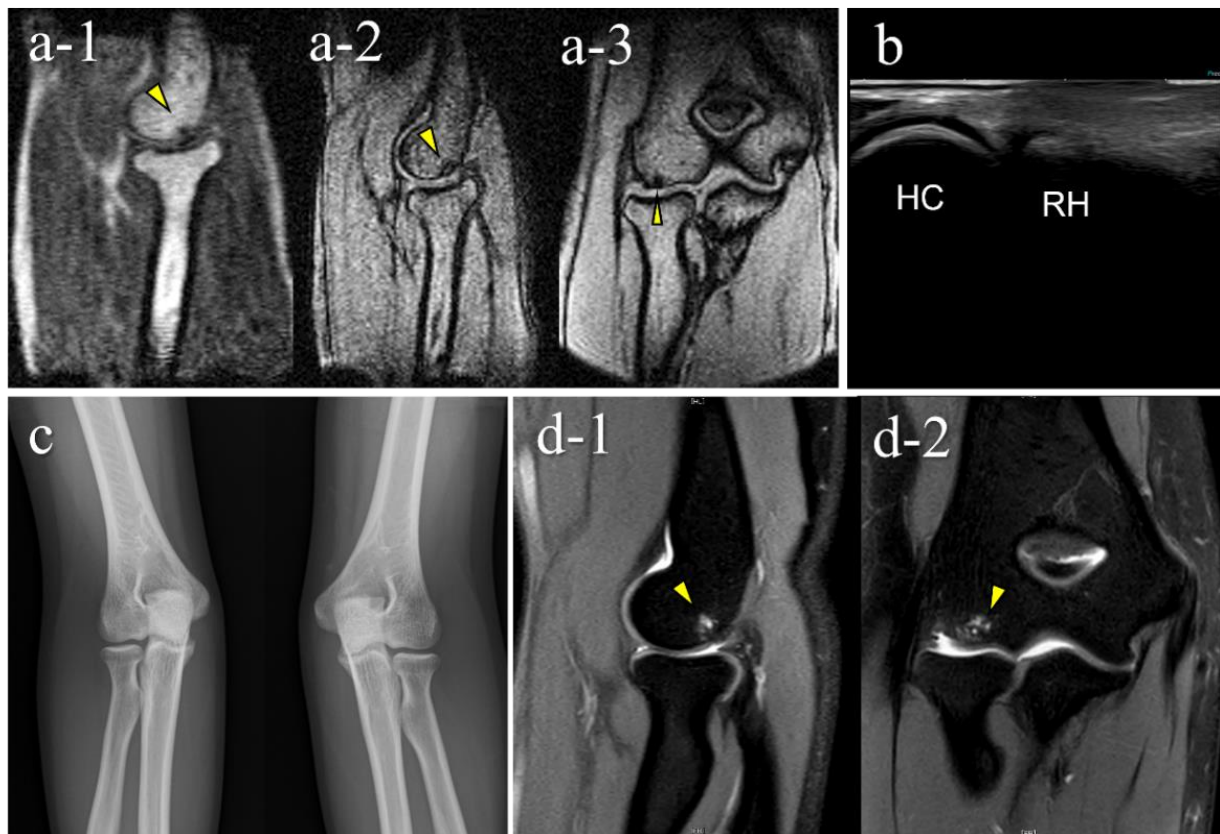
A false-positive case with mobile MRI (Case 6): Mobile MRI (+), US (-). (a) Mobile MR images: a-1, sagittal T1WI image; a-2, sagittal T2*WI image; a-3, coronal T2*WI image: mobile MR images showing a small subchondral bone-lesion in the posterior capitellum; (b) US images of the posterior longitudinal view: US did not reveal any remarkable findings; (c) X-p AP view with elbow 45° flexed: X-p 45° showed no significant findings; (d) 3T MR images: d-1, PDWI-FS sagittal image; d-2, PDWI-FS coronal image: 3-T MR image showing that the lesion was located in the posterior-central region of the capitellum and conflicted with the posterior synovial folds in the extended position. The pathogenesis differed from that of OCD caused by pitching according to the location of the lesion. Repeated hyperextension may have contributed to the pathology, as in Panner’s disease, based on the location of the lesion and the patient’s range of motion findings.
